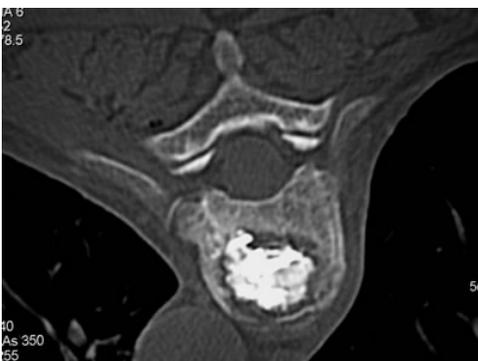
Axial CT. Good distribution of Cortoss® in the vertebral body.
